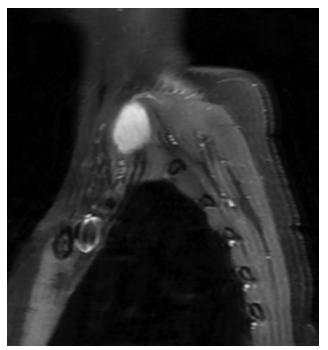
MRI demonstrates a large mass around the right brachial plexus.
